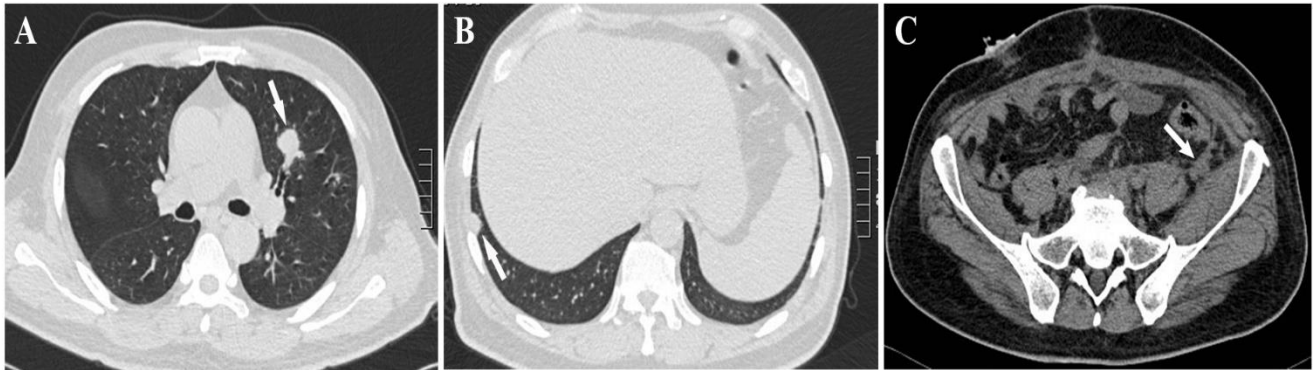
A lung CT showed metastases of SCUB to A) lung and B) pleura, and C) a whole abdominal CT detected metastasis to the peritoneum.
